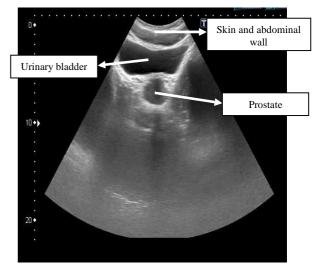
Sample of raw ultrasound image of prostate obtained via transabdominal scanning
